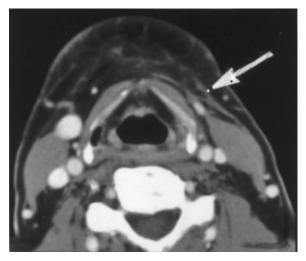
Contrast enhanced axial CT scan of the neck at the level of the thyrohyoid cartilage, performed prior to treatment. There is a bi-dimensionally measurable mass arising from the left platysma muscle (arrow).
